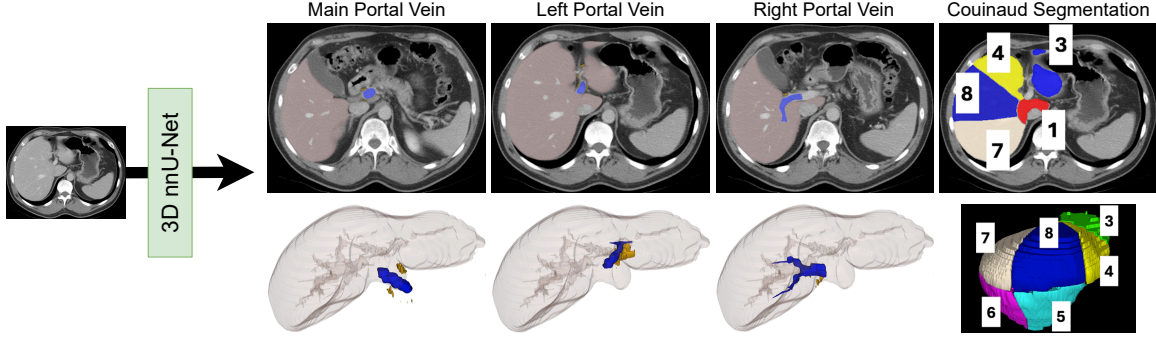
Automated framework for staging advanced fibrosis and cirrhosis. A 3D full resolution nnU-Net segmented the portal vein and its branches. Another model segmented the liver, Couinaud segments, and spleen. CT biomarkers (volume, attenuation, fat fraction) of the liver, spleen and perivascular adipose tissue (PVAT) were automatically derived. Liver (light brown), portal vein (blue), PVAT (yellow), and Couinaud segments (various colors).
